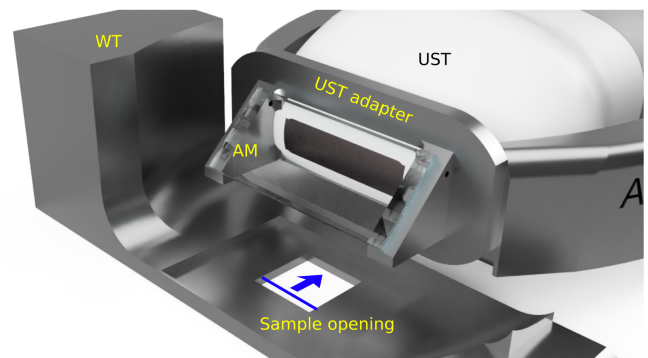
Sketch of the experimental setup. AM, acoustical mirror; BF, bandpass filter; BS, beam splitter; CC, camera chip; CL, collimating lens; DM, dichroic mirror; FA, fiber adapter; FL, focusing lens; FO, focusing objective; LP, long pass filter; M, galvo mirrors; MS, motorized stage; OCT, optical coherence tomography; RR, retroreflector; SP, shortpass filter; UST, ultrasound transducer; WT, water tank. The lines represent the optical paths of OCT (red); RS collection (yellow); visible path for camera (blue) and the 532 nm excitation beam (green). The US creates a B-mode image in the yz plane; by translating the UST together with the AM in x direction the imaging can be performed at different planes
